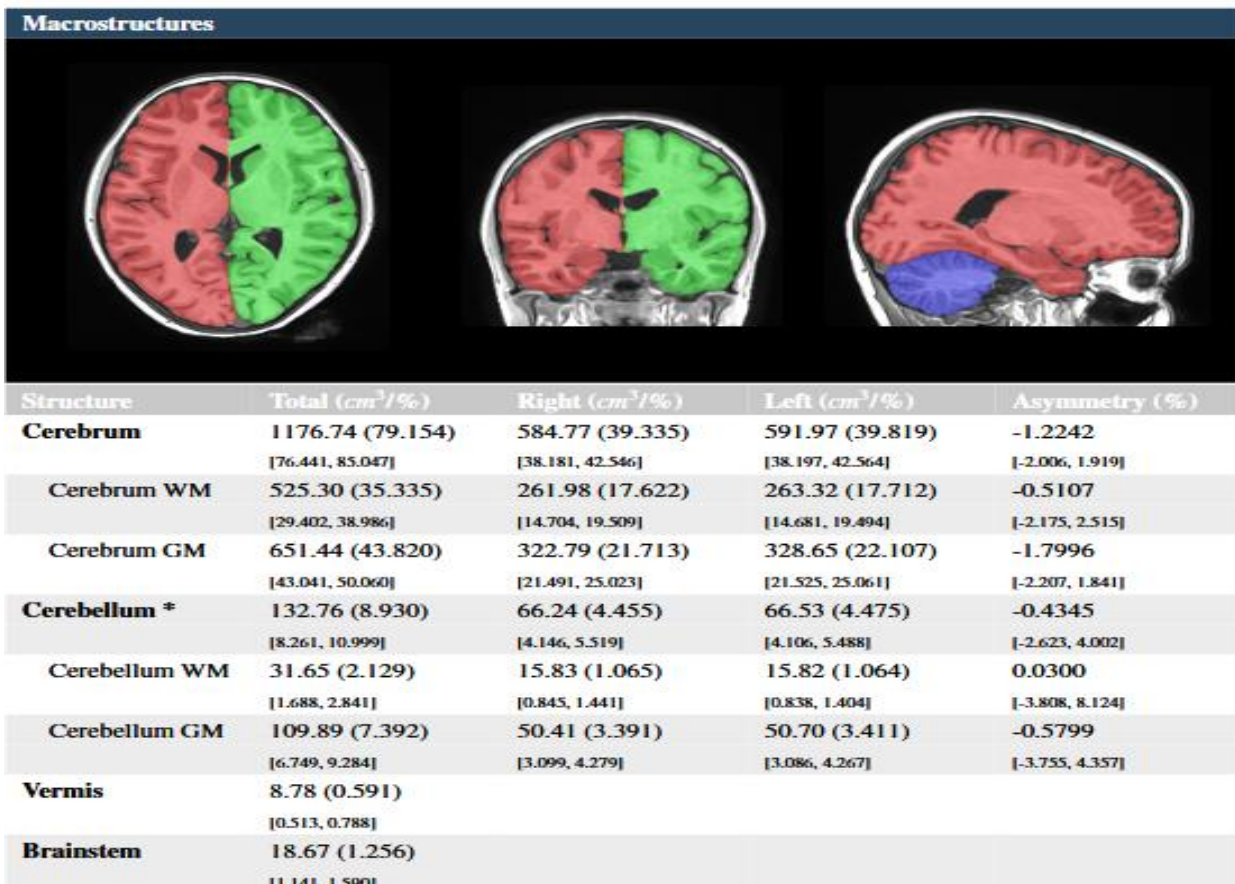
12 years old female, no history of medical disease, moderate socioeconomic status, no hypertension or anemia, comes to MRI unit complaining of headache, MRI exam revealed normal brain at [axial T2WI[A], axial FLAIR[B], axial T1WI[C], no diffusion restriction at DWI[D] and ADC map] [E] Vol
